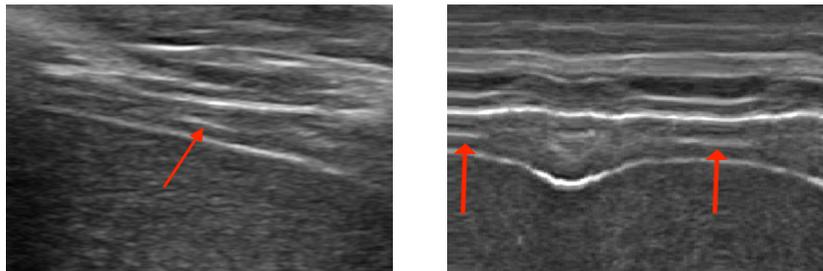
Central tendon in right hemidiaphragm ultrasound, indicated by a red arrow in B-mode (left) and its reconstructed M-mode (right)
